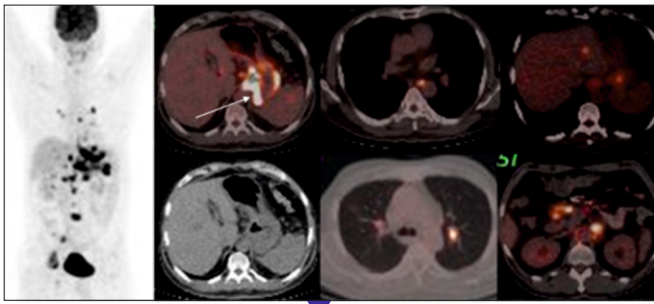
Images of 48 years old female with carcinoma left breast, post-surgery, chemotherapy and radiation therapy 2 years previously, now presented with backache. FDG-PET/CT MIP (a) and fused axial (b) images showed recurrent metastatic disease in sternum (SUVmax 7.90), liver (SUVmax 7.97) and right lung (SUVmax 8.69).
